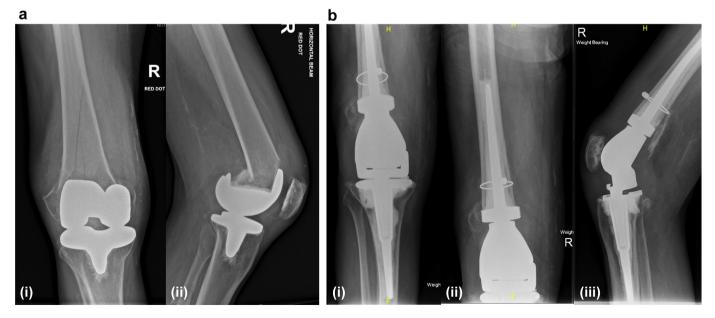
(a) Preoperative anteroposterior (i) and lateral (ii) radiograph of right knee in a 78-year-old male with comminuted periprosthetic fracture of the distal femur propagating proximally around posterior-stabilised knee. (b) Postoperative radiographs (anteroposterior i/ii and lateral iii) at 5 years follow-up demonstrating the use of a cable around the distal femur ensuring anatomical reduction "reconstituting tube" then cementing distal femoral replacement component and allowing the patient to mobilise fully weight-bearing in the immediate postoperative period.
